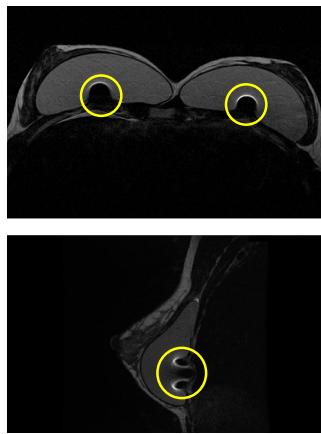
Images of an axial and sagittal view of MR images depicting the microtransponder's artifact.
